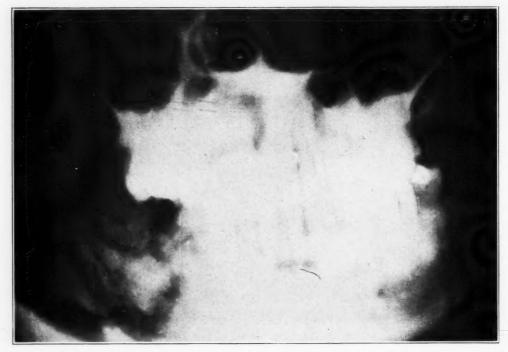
Anteroposterior roentgenogram, made February 24, showing fracture and osteomyelitis.
